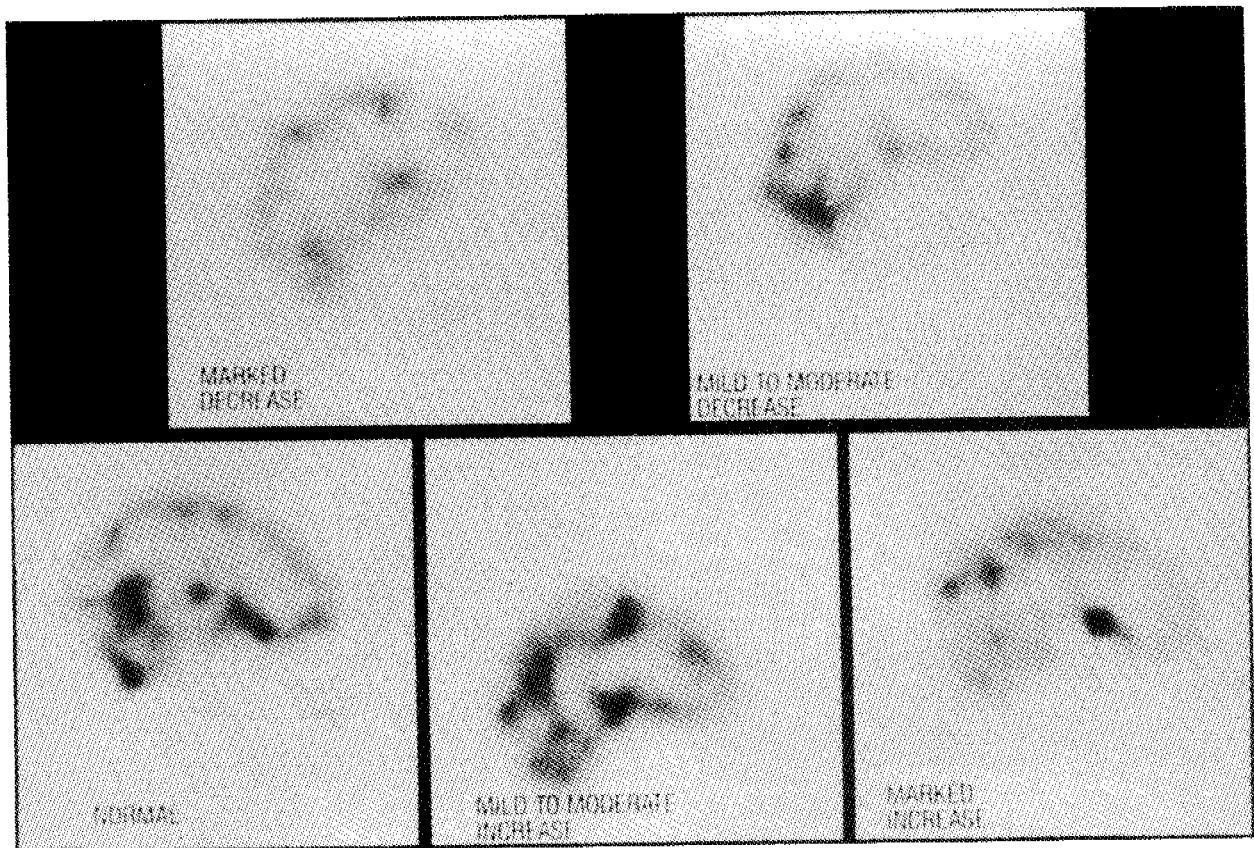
These SPECT studies show examples of increased and decreased perfusion in the frontal lobes of different medication-free patients. [courtesy of Dr. R.A. O'Connell (1)]
